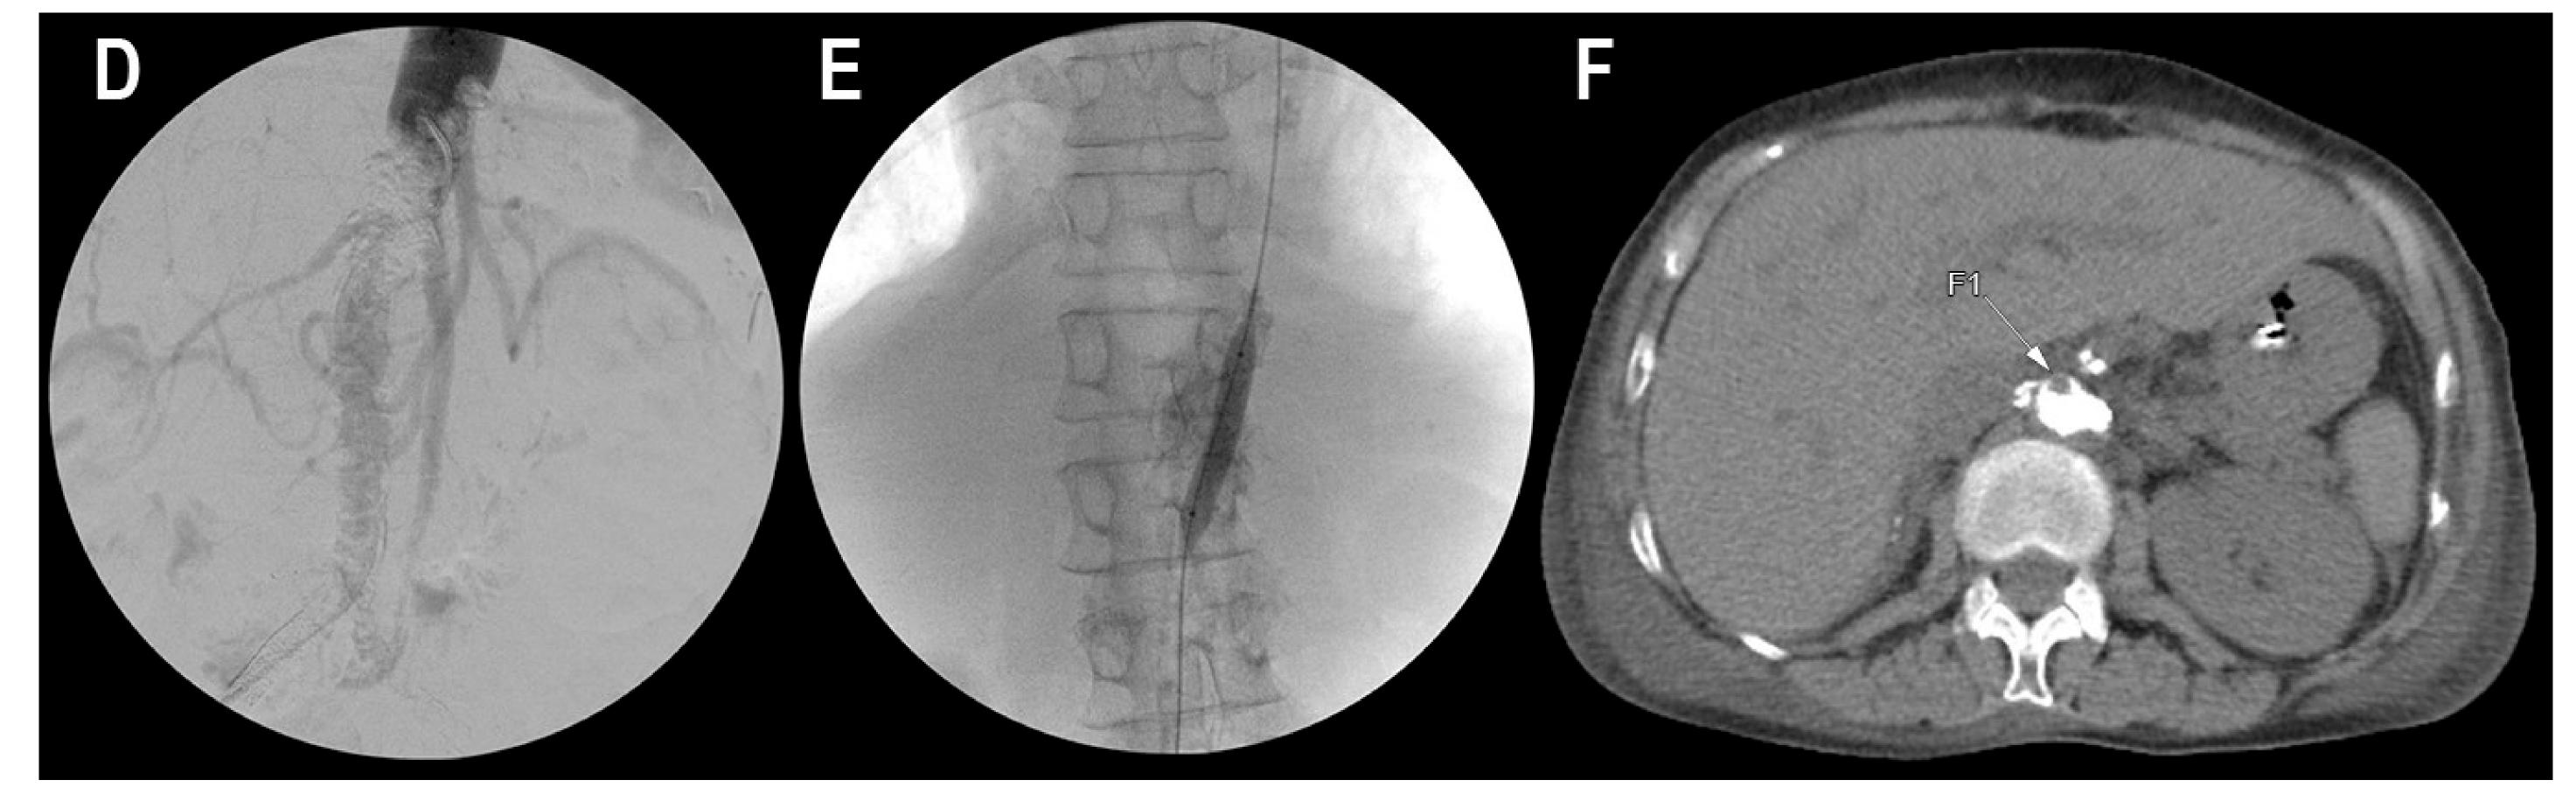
Aortic angiography demonstrating occlusion of distal blood flow (D) and subsequent angioplasty (E). Postoperative non-contrast CT demonstrating successful angioplasty (F1).
